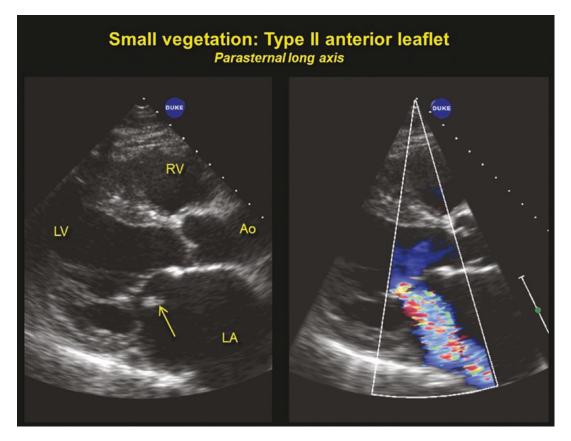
Parasternal long axis from a patient wil a small mitral vegetation (arrow). This resulted in the mitral insufficiency seen in the color flow in the right panel
